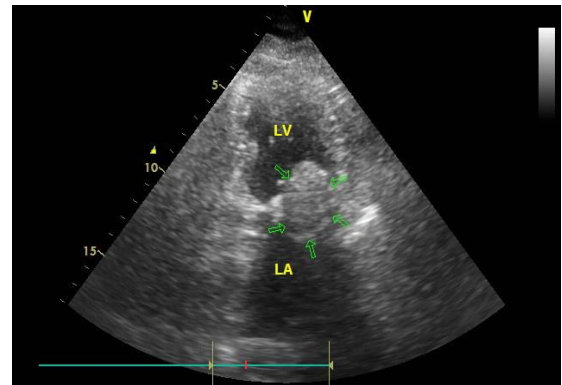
Transthoracic echocardiography showed that a mass attached to mitral valve in apical two chamber view.
